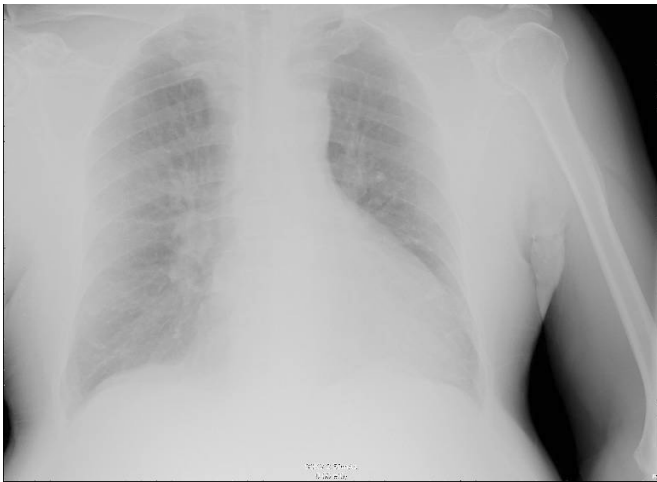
Chest X-ray of 49 years old male patient.
